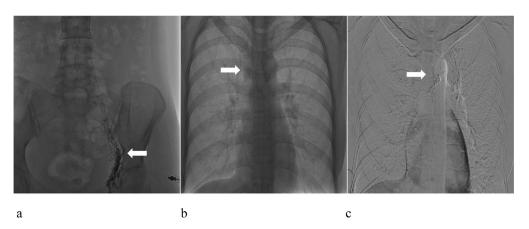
(A) Ultrasound-guided puncture of the right inguinal lymph node. (B) Intraoperative DSA image of the thoracic duct. (C) Iodine oil leakage from the thoracic duct at the T4 level.
